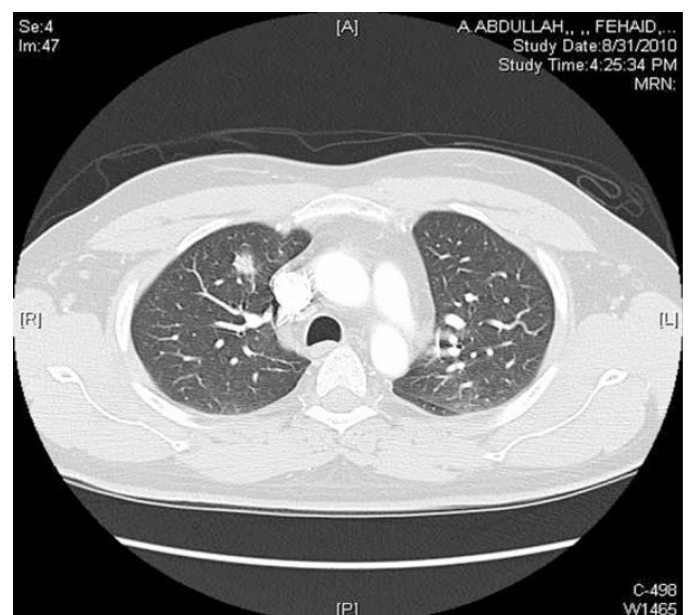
Computed tomography (CT) scan of the lungs showing multiple nodules in both upper lobes, one of which was cavitating.
